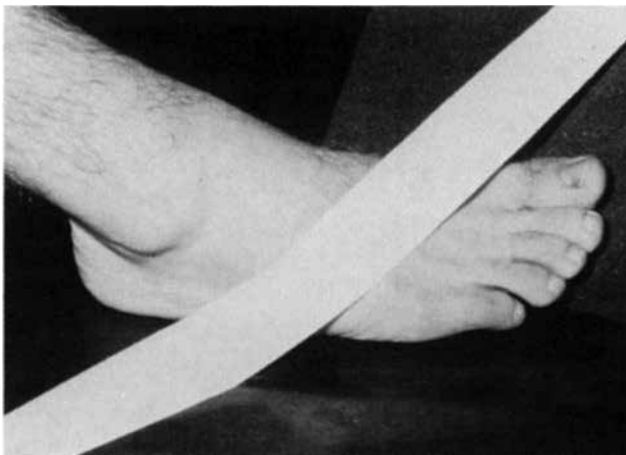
A foot placed on a foam wedge and taped to the cassette in the correct position to make a so-called anatomical anteroposterior radiograph. The medial side of the fore part of the foot is elevated so that the entire foot is inverted. Fluoroscopy should be used to ensure proper positioning of the foot.
